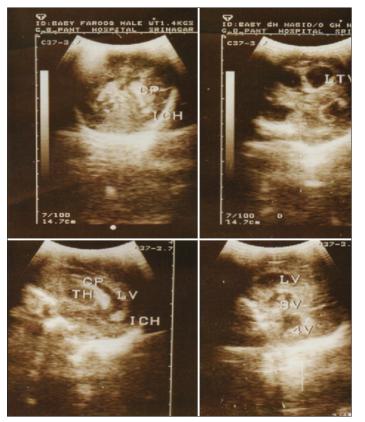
Ultrasonography cranium showing flares in the periventricular area
